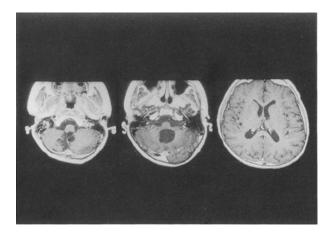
Enhanced MRI shows mild atrophy of both cerebellar hemispheres (mainly on the right) and slight enlargement of the 4th ventricle, but no supratentorial lesions.
